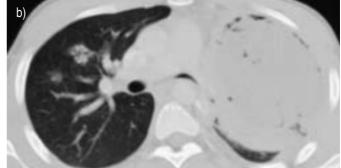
Computed tomography scans of the chest obtained in 1988 showing a) right and left upper lobe hazy infiltrates, b) right upper lobe bronchocentric lesions, and c) nodules with minimal (pseudo)cavitation.
